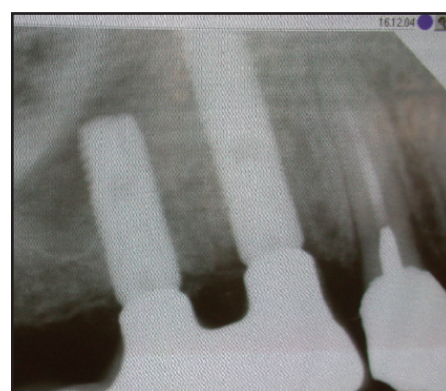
PA radiograph was taken using a guiding device to act as a baseline radiograph
